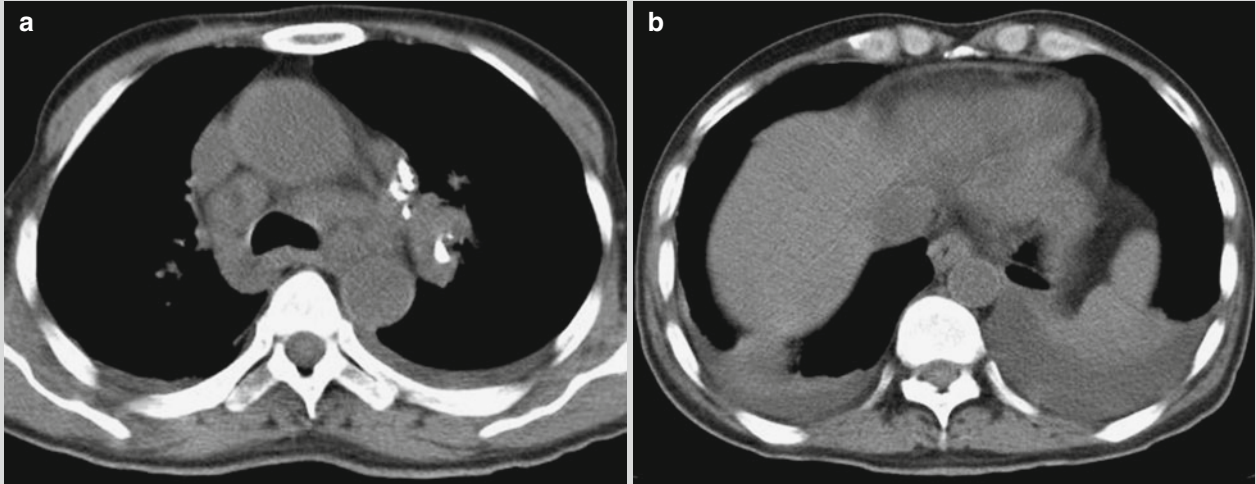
Tuberculous exudative pleuritis (free pleural effusion). (a, b) CT scanning demonstrates small quantities of pleural effusion at bilateral thoracic cavity and enlarged mediastinal lymph nodes
